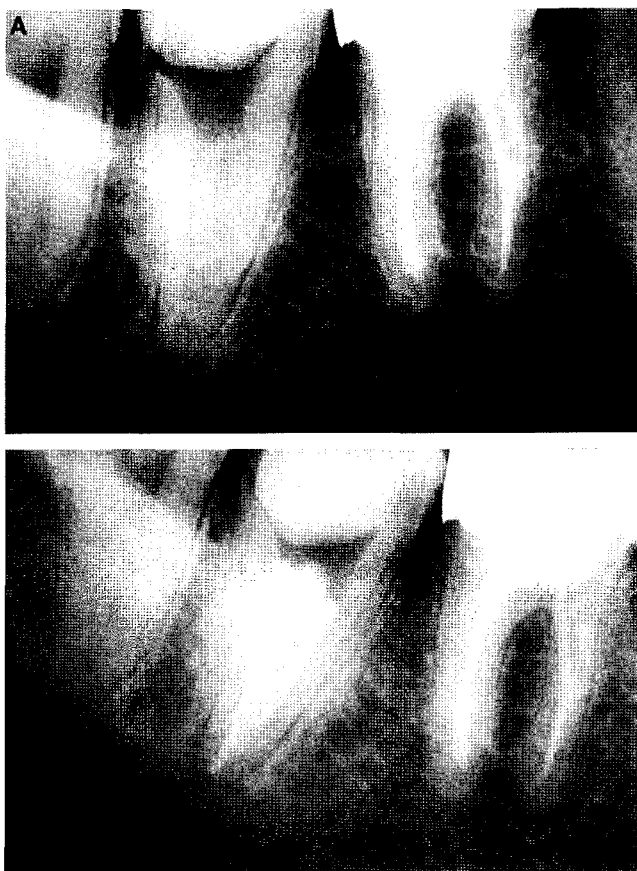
Category II. (A) Preoperative radiograph showing a radicular fusion, a large distal canal, a narrow mesial canal, and a blurred image of a third canal in between. (B) Postoperative radiograph. Note the presence of dentin separating a mesial canal from the rest of the C-shaped canal.
